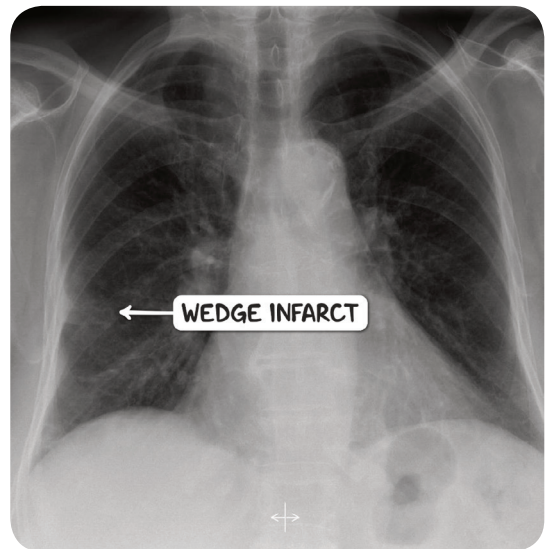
A plant chest radiograph of the same individual, demonstrating the pulmonary infarct which is visible as a wedge shaped opacity in the lateral art of the right lung field.
